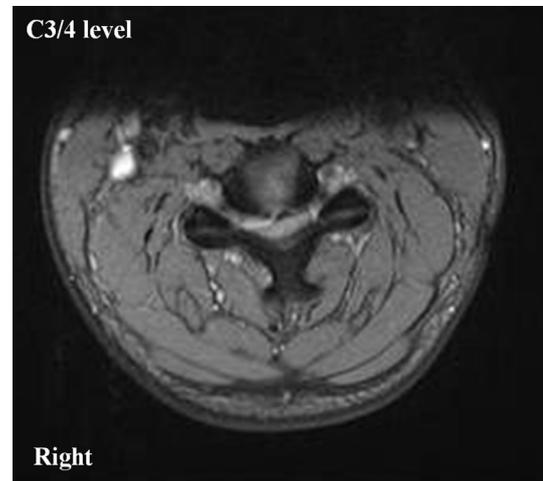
Preoperative MRI showing prolapsed intervertebral disc with compression of the cord.
